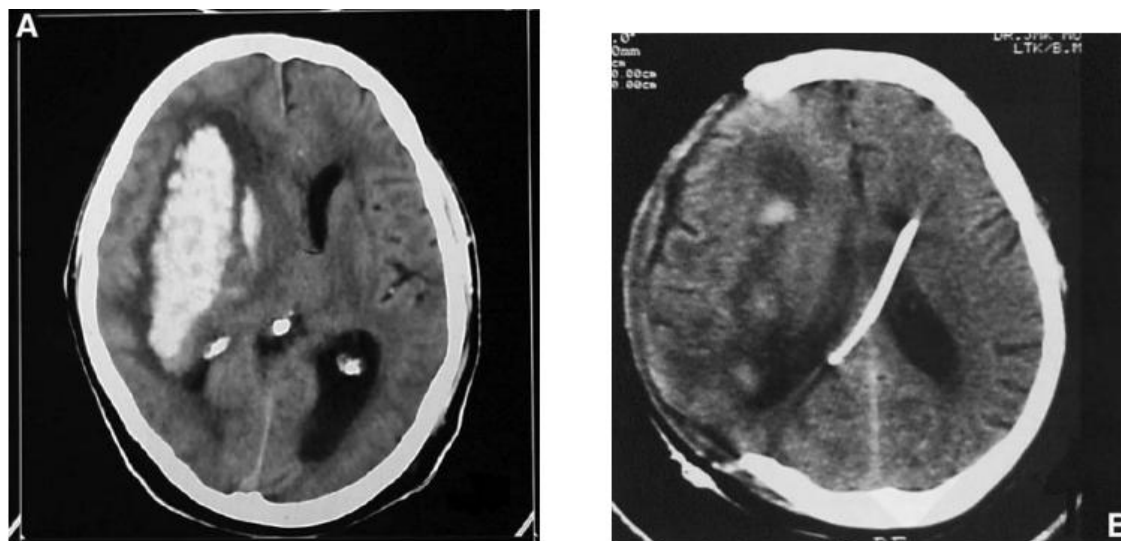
(A), Plain CT scan brain showing large right basal ganglion hemorrhage with midline shift and contralateral ventricular dilatation.(B), CT scan brain on the second postoperative day, showing evidence of residual hemorrhage and perihematomal edema.
